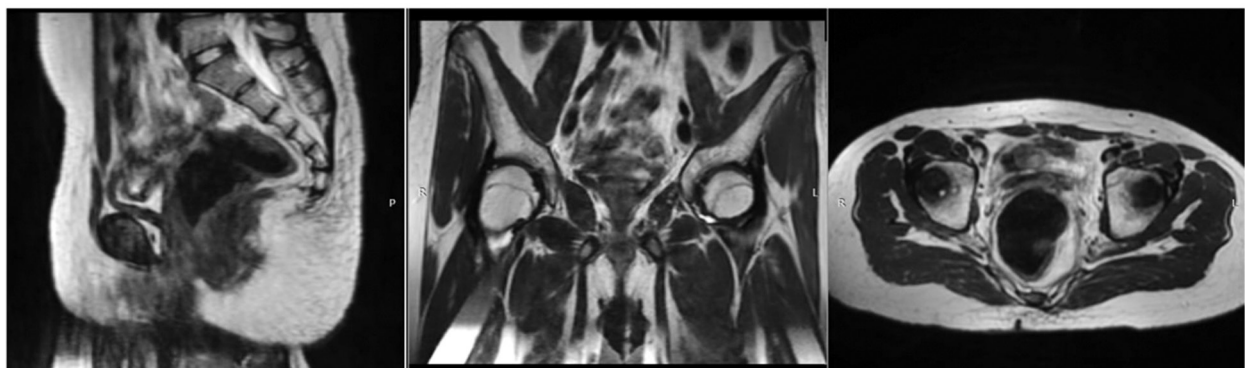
Pelvic magnetic resonance imaging findings were consistent with absence of normal ovaries and uterus on sagittal, coronal, and transverse cuts.
